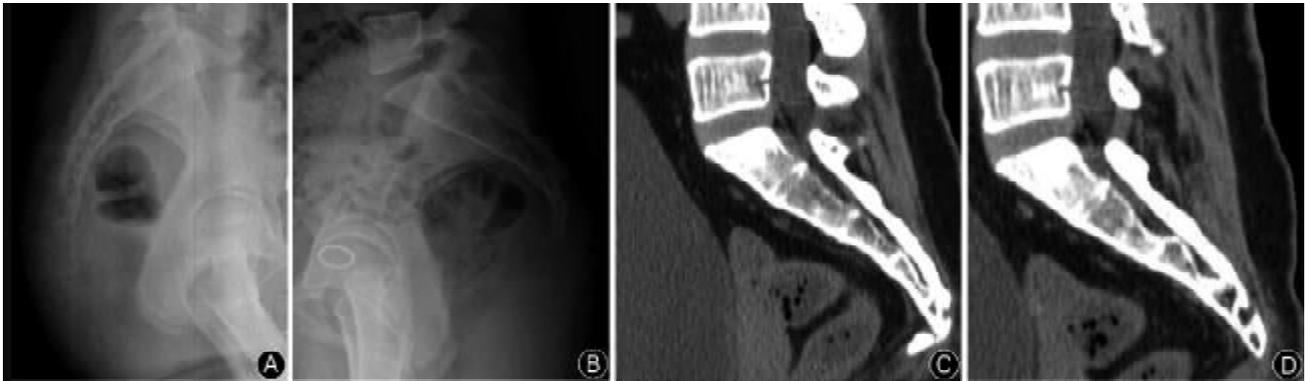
A 45-year-old female patient who had coccydynia after falling from a bike. Conservative treatments for 8 months have no satisfactory effects. Preoperative (A) and postoperative (B) lateral radiographs; preoperative (C) and postoperative (D) sagittal CT images.
